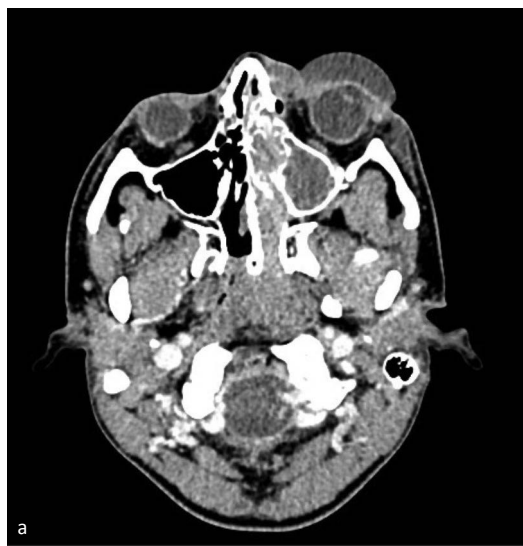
The first CT scan performed on admission
